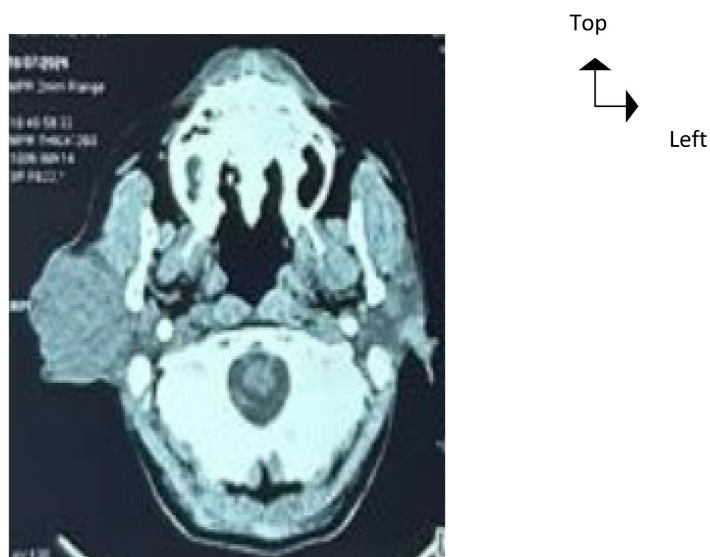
Cervicofacial CT showing a right parotid tissue mass.
